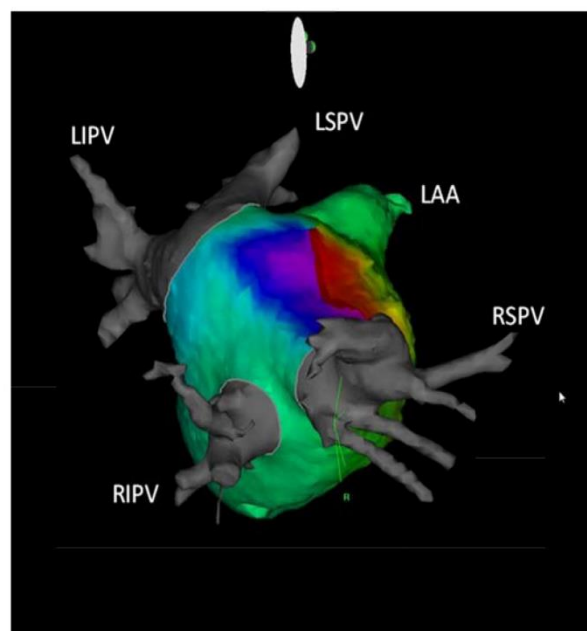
Roof dependent flutter propagating around the right sided pulmonary veins on three dimensional CARTO activation map with CT integration in right lateral view. RSPV: right superior pulmonary vein, RIPV: right inferior pulmonary vein, LSPV: left superior pulmonary vein, LIPV: left inferior pulmonary vein, LAA: left atrial appendage.
